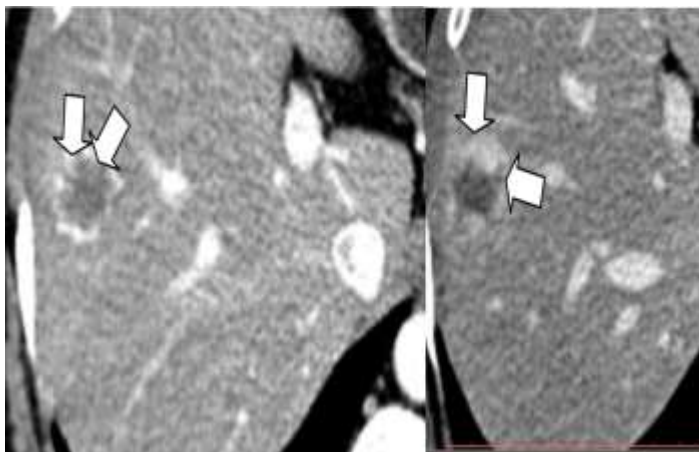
Peripheral puddles pattern. Transverse arterial phase CT scan of a hemangioma with peripheral enhancing globules (arrows) with attenuation similar to that of the aorta which follow the blood pool with centripetal filling in the portal phase. In contrast to the complete ring enhancement shown by metastasis the enhancing globules in the periphery of this pattern are discontinuous.
